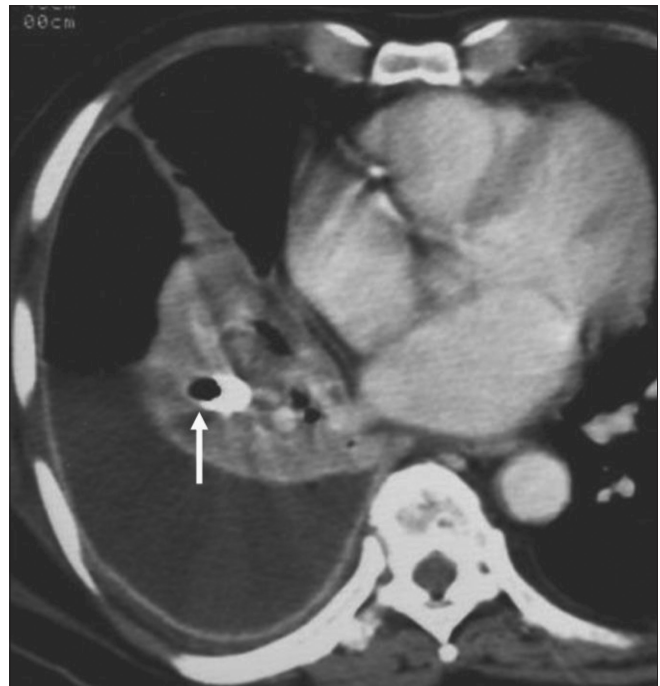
Contrast-enhanced axial CT image of the same patient as figure 6 demonstrates the tip of the intercostal drainage tube (arrow) within the lung
